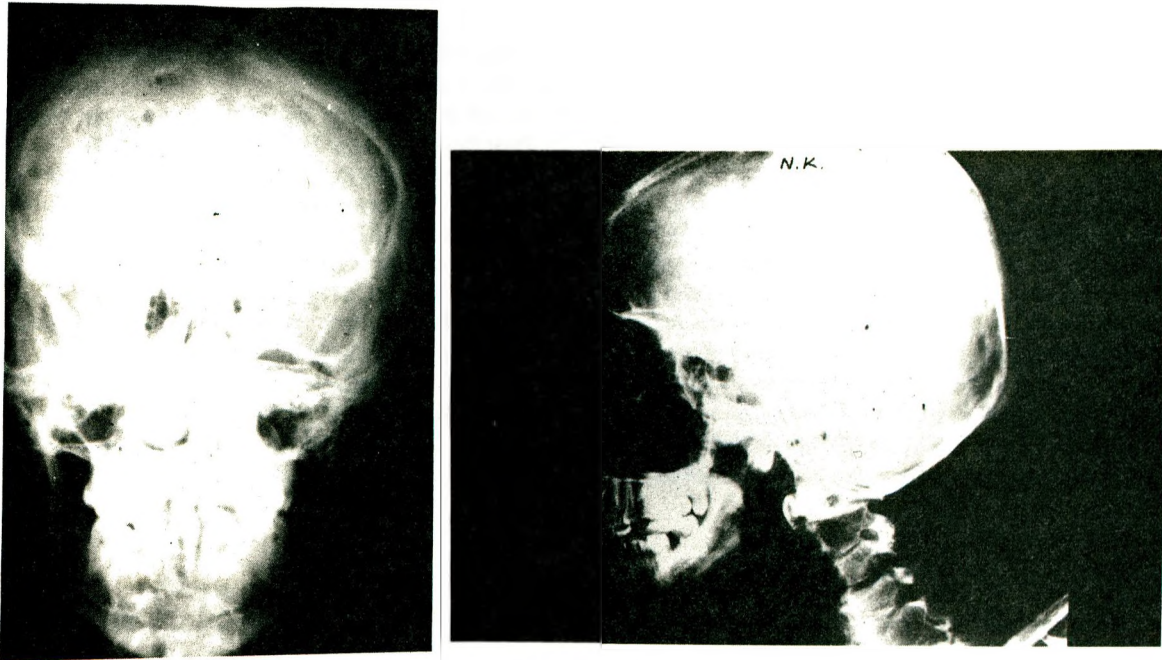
(a) X-rays of anterior and (b) left lateral of the head (hypoplasia of body and ramus mandible)
